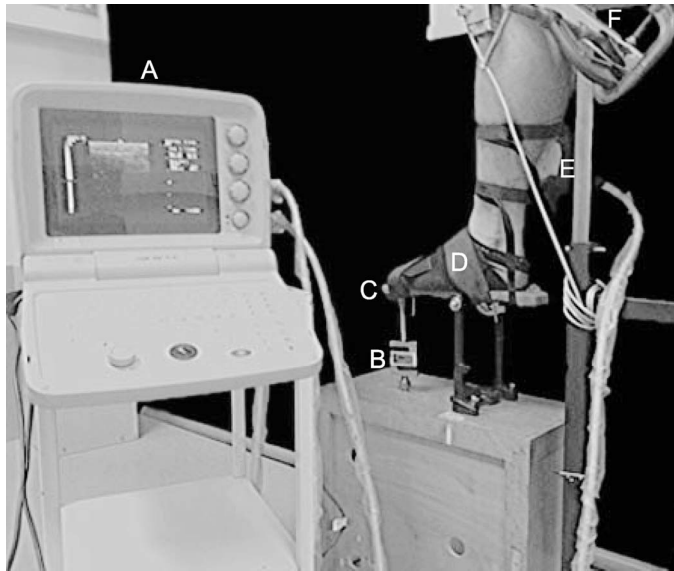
Experimental design for isometric plantar-flexion strength. A, B-mode ultrasound. B, S-beam load cell. C, Foot plate. D, Rigid fixtures for the foot and ankle. E, A 7.5-MHz linear transducer. F, Rigid fixtures for the knee.
